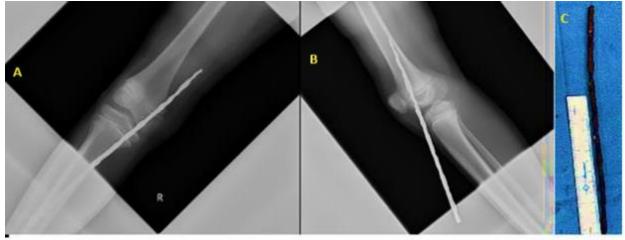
X-ray Rt knee and thigh; A- AP and B-lateral views of young male boy, presented with rusty iron rode penetrated the medial side of his thigh as the boy fallen on it. C-Notice the full length of the rode after surgical extraction is more than 20 cm.
